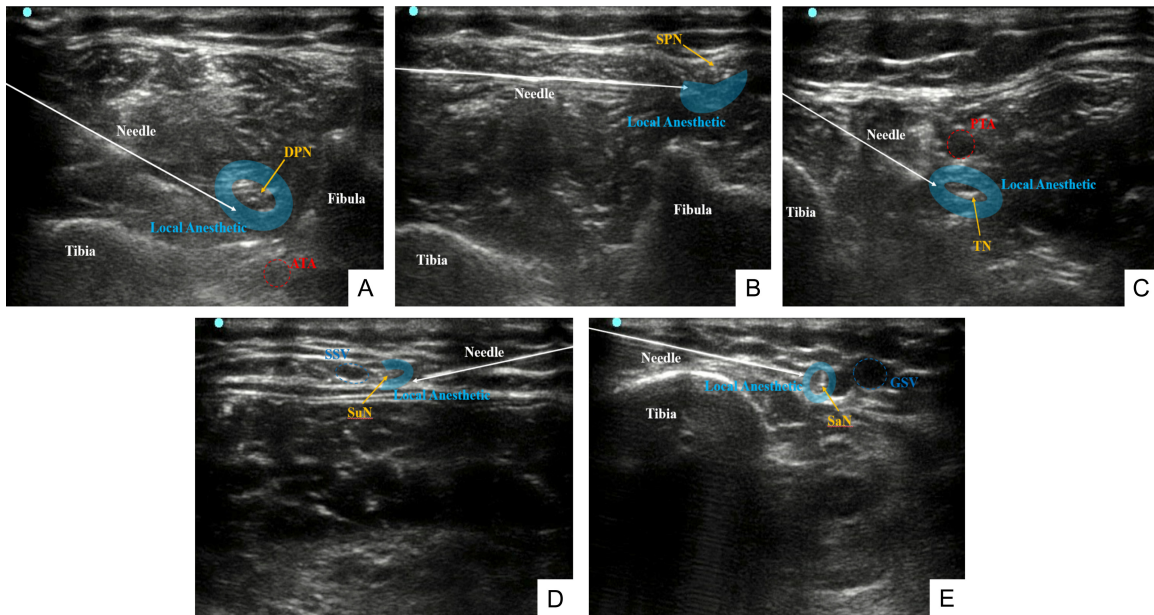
Ultrasound-guided HAB image. Under ultrasound vision, local anesthetic injections were performed near the (A) DPN, (B) SPN, (C) TN, (D) SuN, and (E) SaN. HAB: high ankle block; DPN: deep peroneal nerve; ATA: anterior tibial artery; SPN: superficial peroneal nerve; TN: tibial nerve; PTA: posterior tibial artery; SuN: sural nerve; SSV: short saphenous vein; SaN: saphenous nerve; GSV: great saphenous vein.
